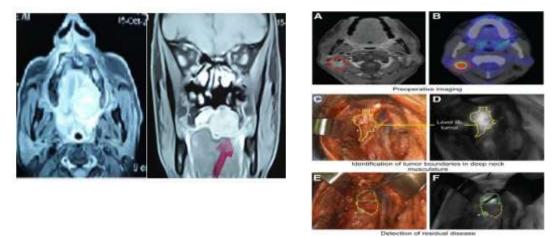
(a) Axial & coronal MRI of palatal mass; (b) Disease detection.
